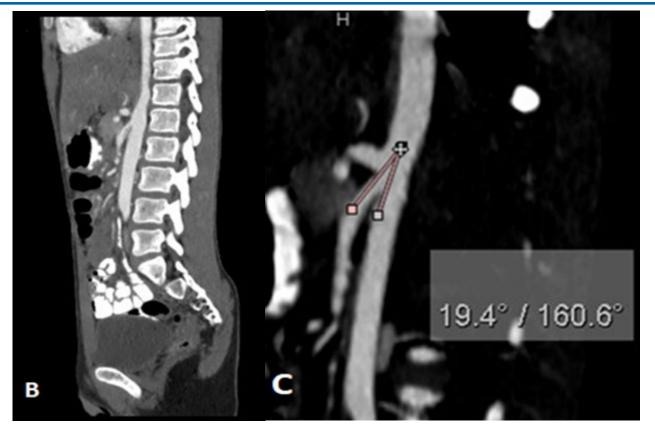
Figure B &C: Sagittal CT of the abdomen with intravenous and oral contrast shows reduced aorto-mesenteric angle measures 19.4° (normal >38°)
